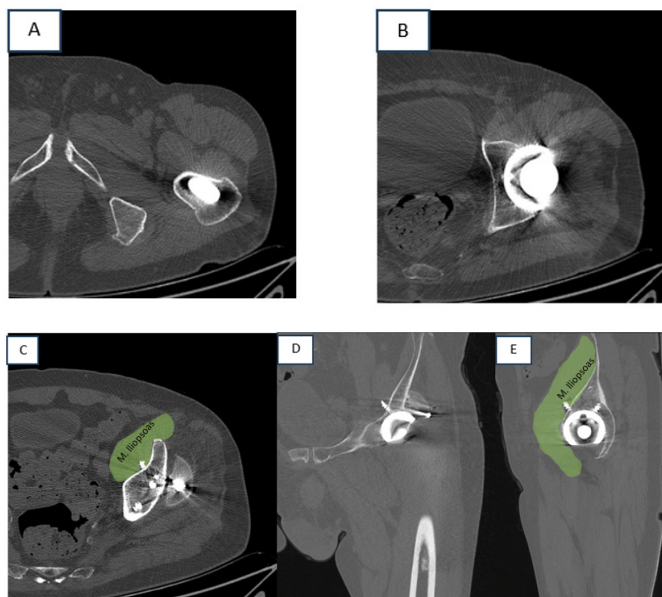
Postoperative control CT scan. The Axial view shows protrusion of the anterior acetabular region (A). Positioning of the femoral component in the medullary canal (B). Protrusion of the anterior acetabular screw is seen in axial (C) coronal (D) and sagittal (E) views.
